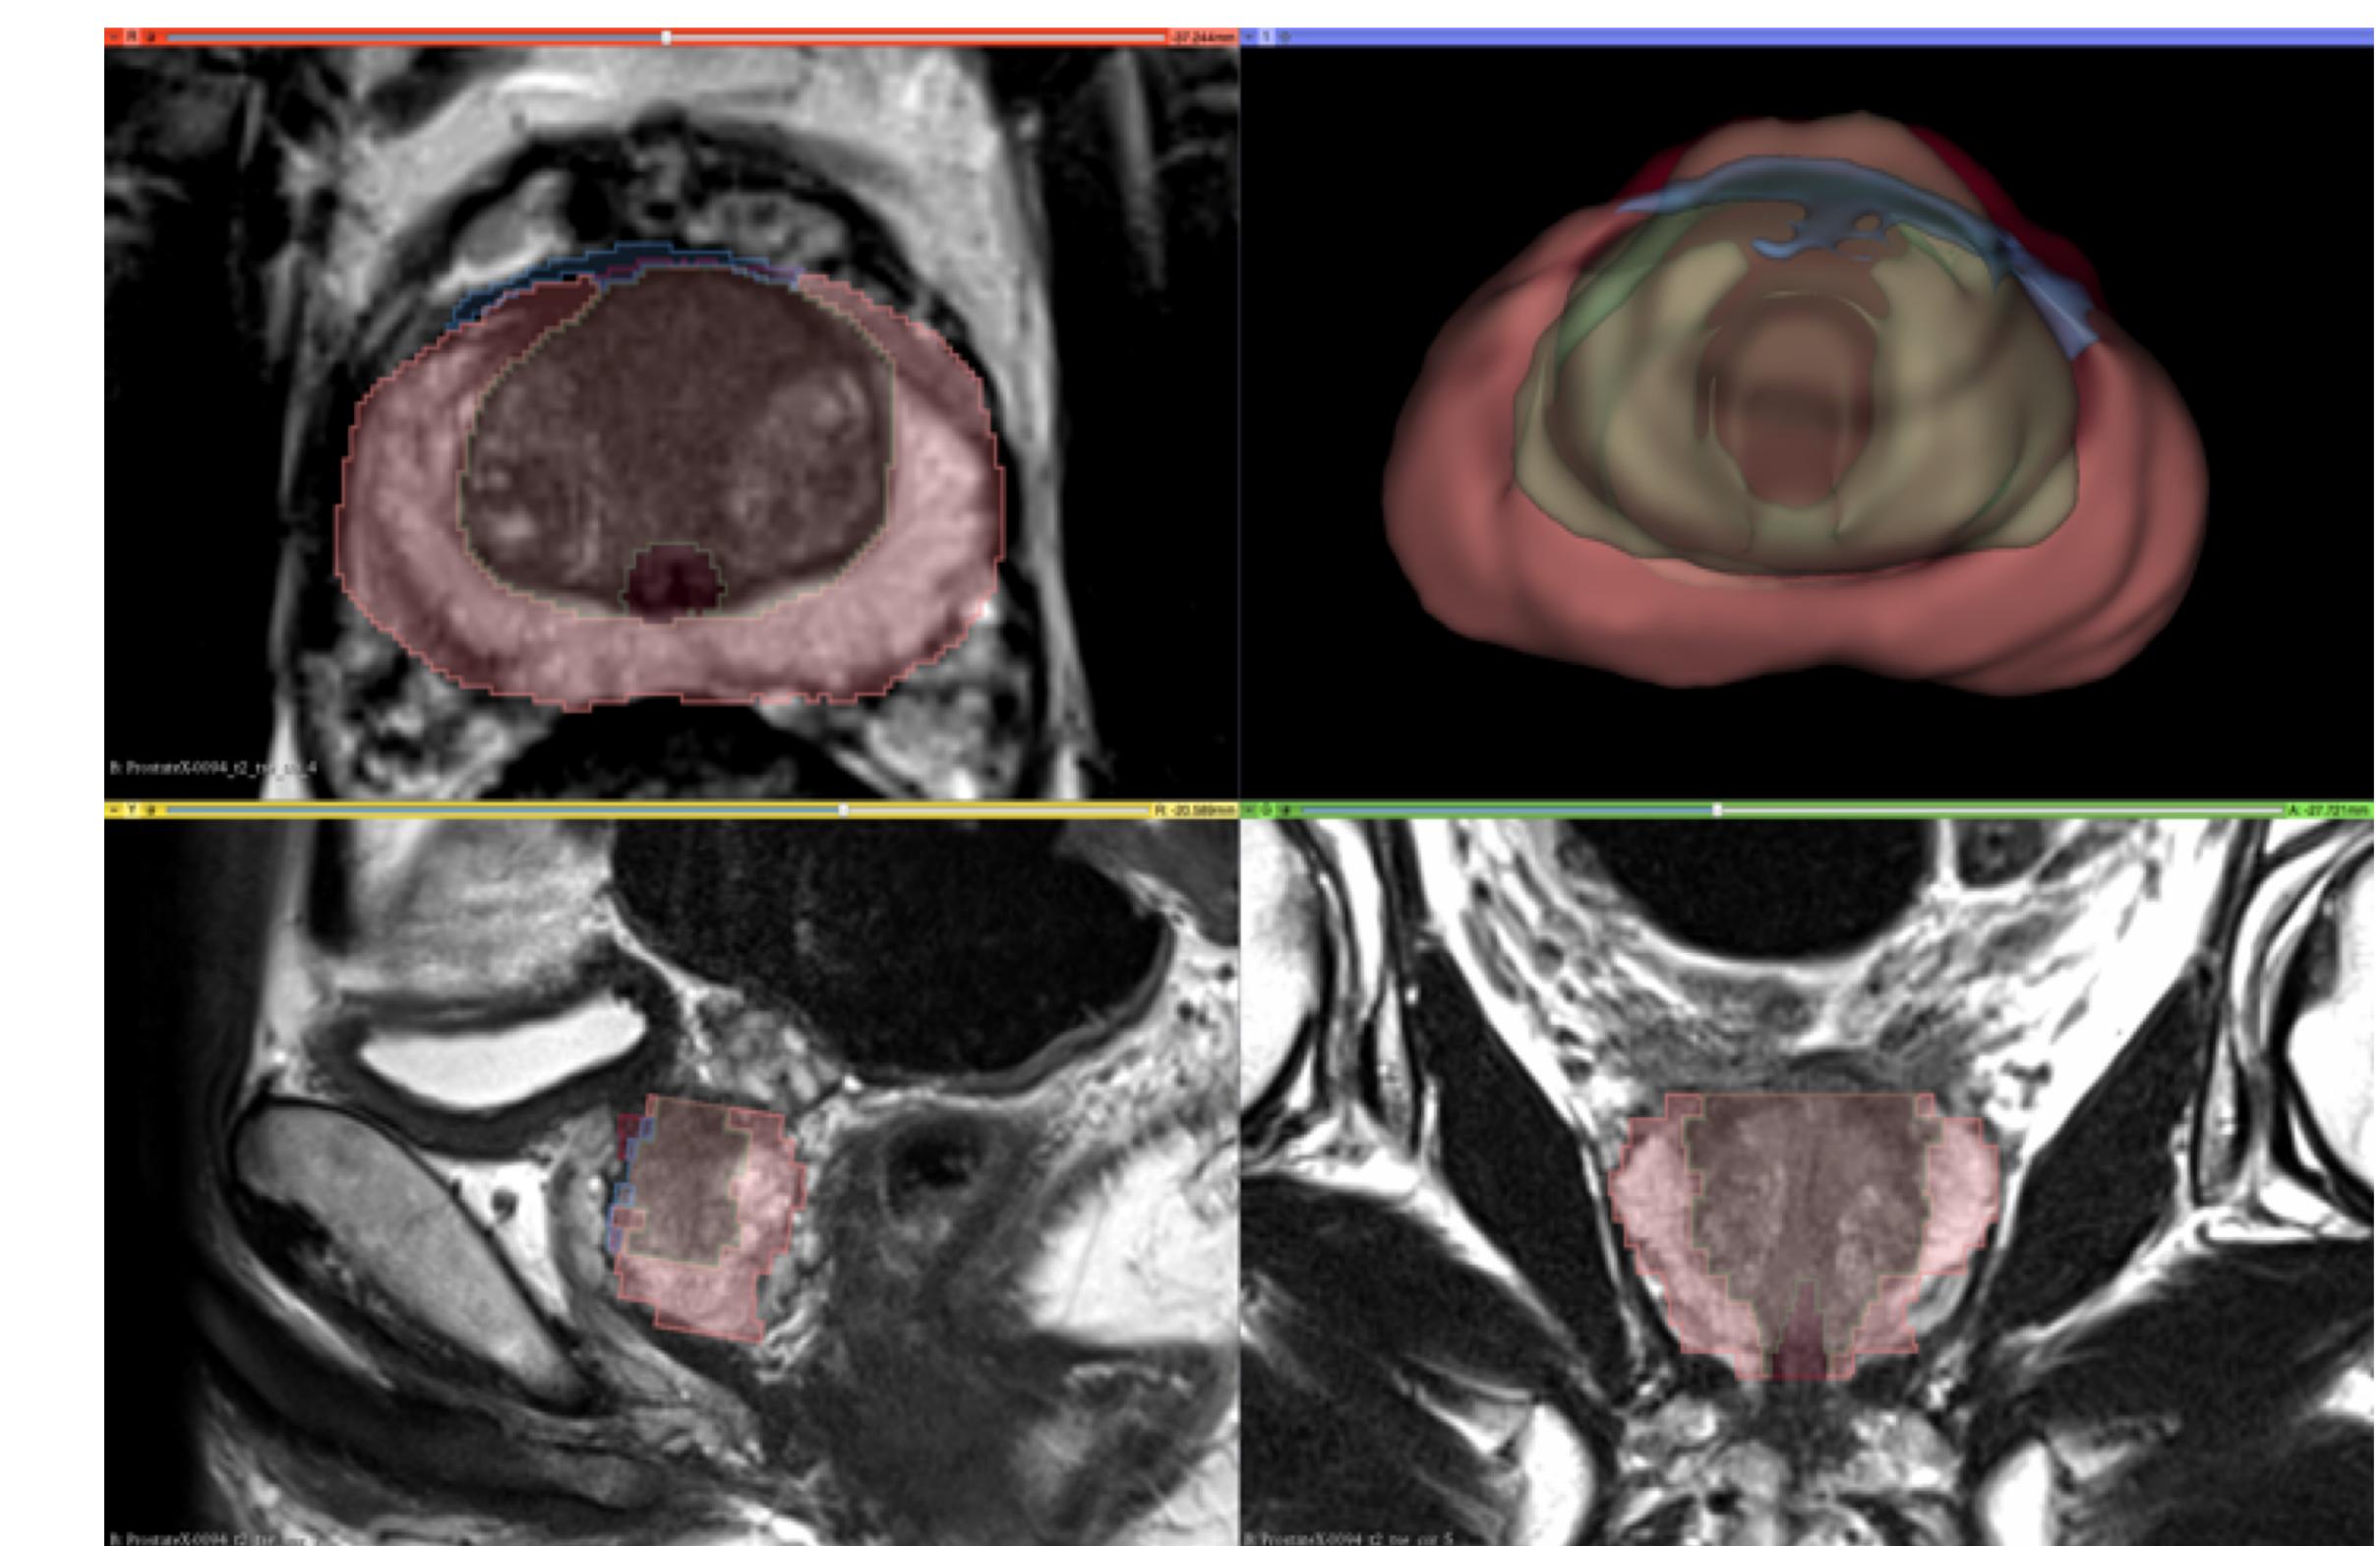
3D volume model of the prostate gland, generated using MRI dataset
